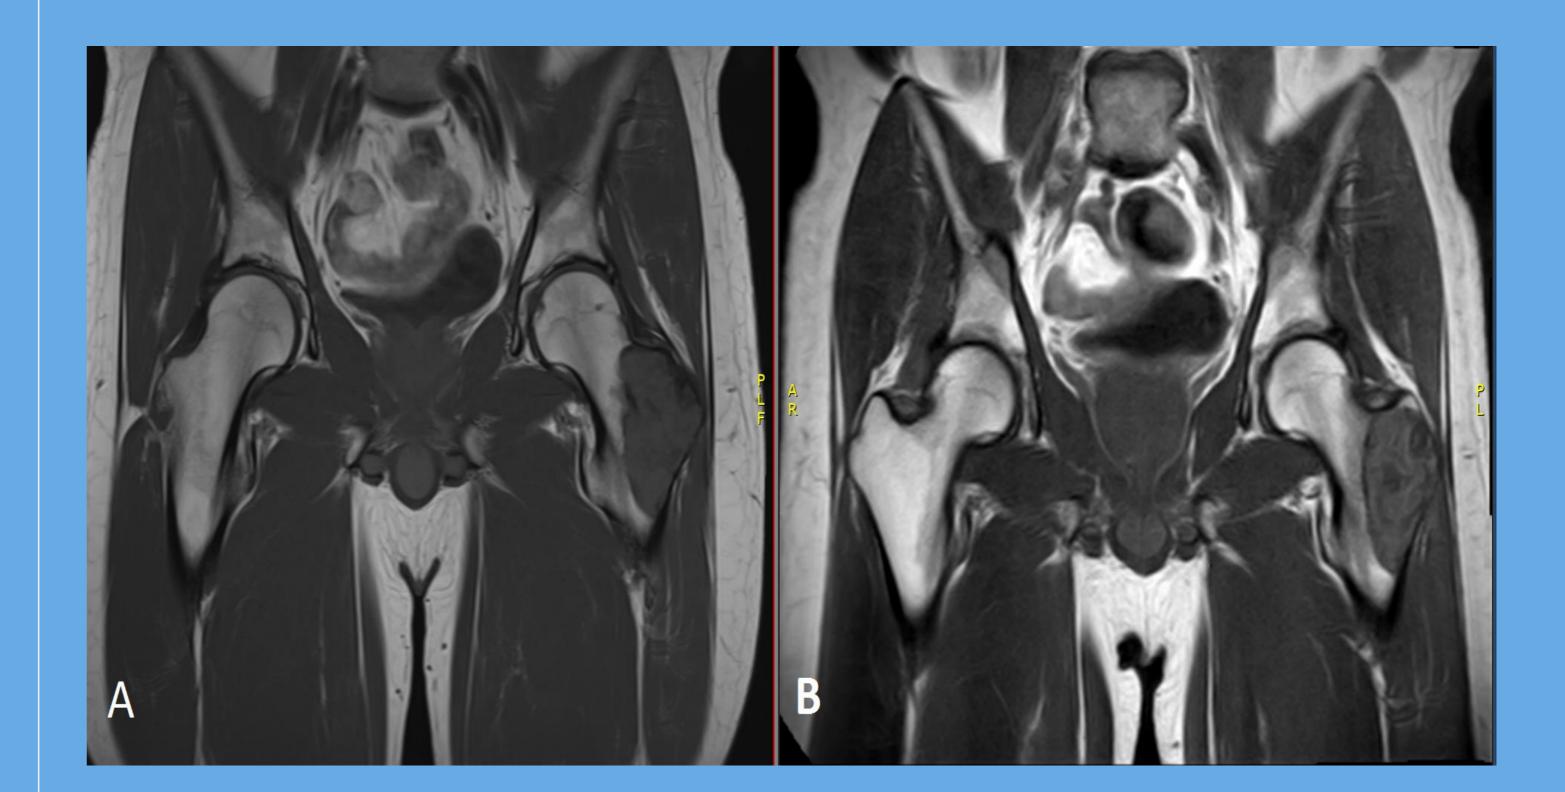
MRI of the pelvis A shows the GCT in the left trochanteric region, B result after XGEVA
